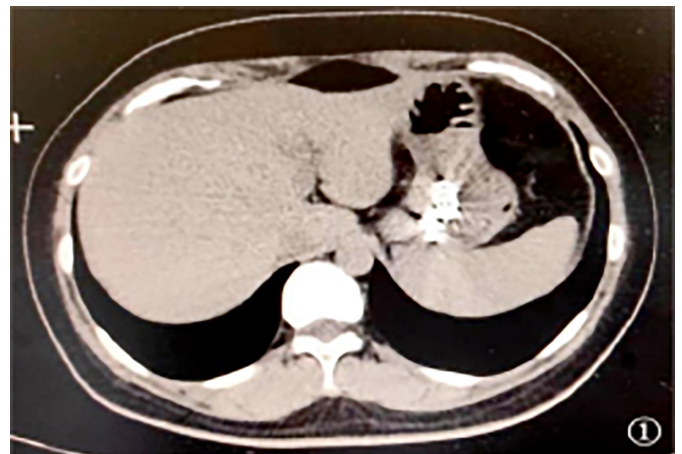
CT scan showing multiple titanium metal clips in the stomach cavity.
